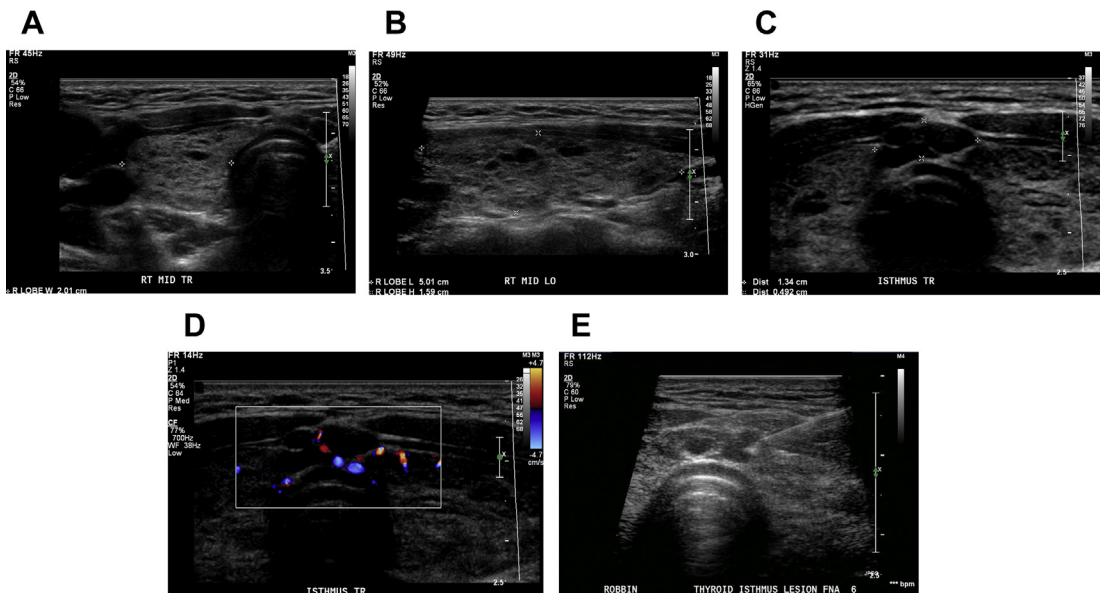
A 17-year-old girl with Hashimoto thyroiditis and a focal nodule. (A, B) Hypoechoic nodules are scattered throughout the gland with increased echogenic bands in-between the nodules, the “giraffe skin” appearance, in the right lobe transverse (A) and longitudinal planes (B) on gray-scale imaging. (C, D) Focal 2.1-cm hypoechoic nodule in the isthmus, on gray-scale (C) with internal color Doppler flow (D), classified as ACR TI-RADS TR-4. (E) FNA is shown with needle in the nodule; sampling revealed focal lymphocytic infiltrate consistent with Hashimoto thyroiditis, without features of a focal nodule. Cursors on (A, B) represent thyroid lobe measurements in the transverse and longitudinal planes; (D) Isthmus nodule measurement is shown in the transverse plane. Longitudinal measurement of the nodule was 2.1 cm, not shown.
